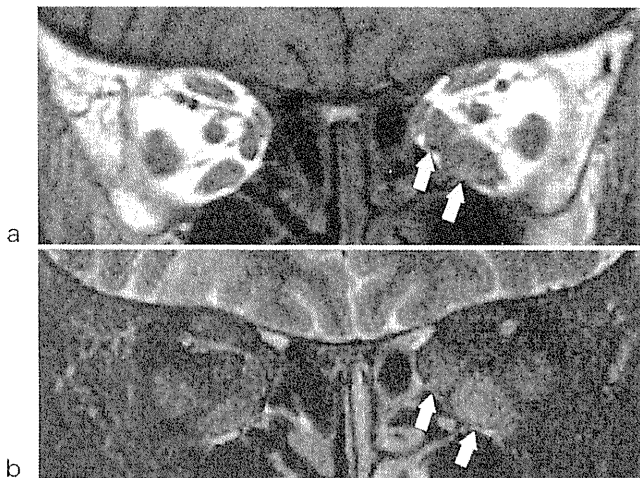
症例 1 の眼窩磁気共鳴画像 (MRI)
